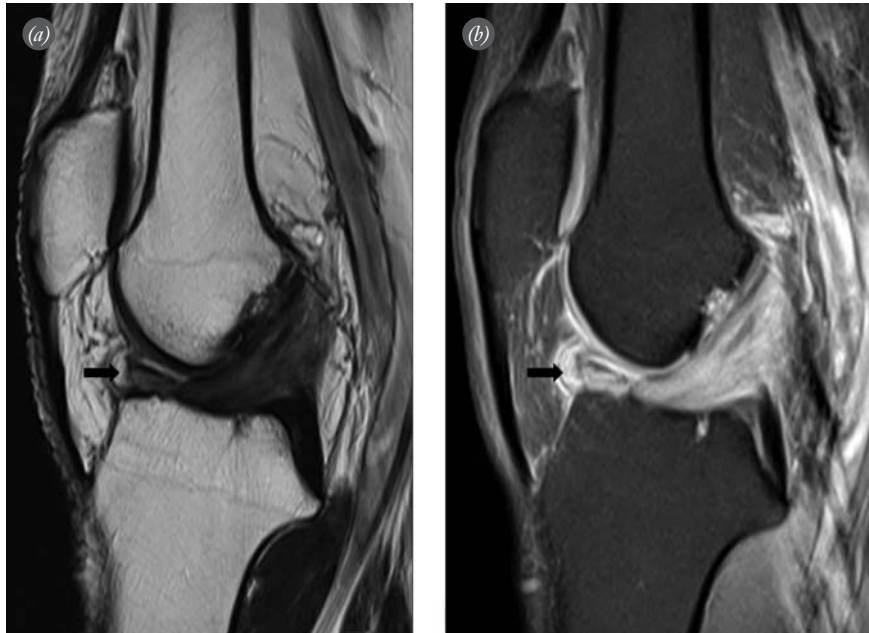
Sagittal T2-weighted image (a) and T1-weighted image (b) showing a thickened and ill-defined ACL with high inhomogeneous signal intensity and a huge mass (arrow) anterior to the tibial attachment of the ACL, which impinged on the intercondylar notch.
